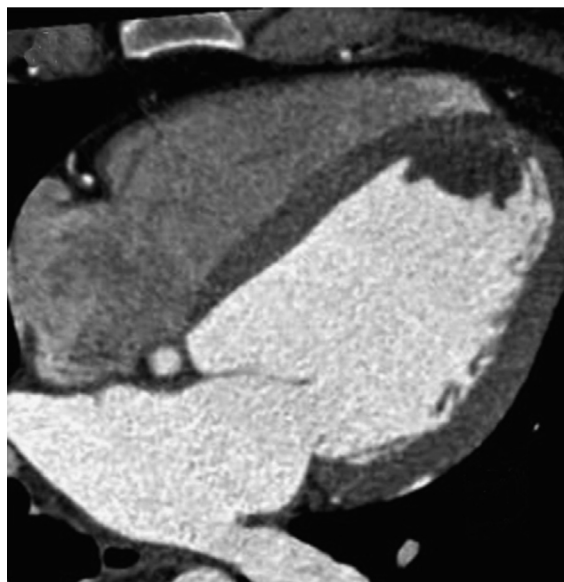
Contrast-enhanced cardiac CT showing a mural thrombus, attenuation value 35 HU, in the distal apical septum, displayed in a four-chamber view.
